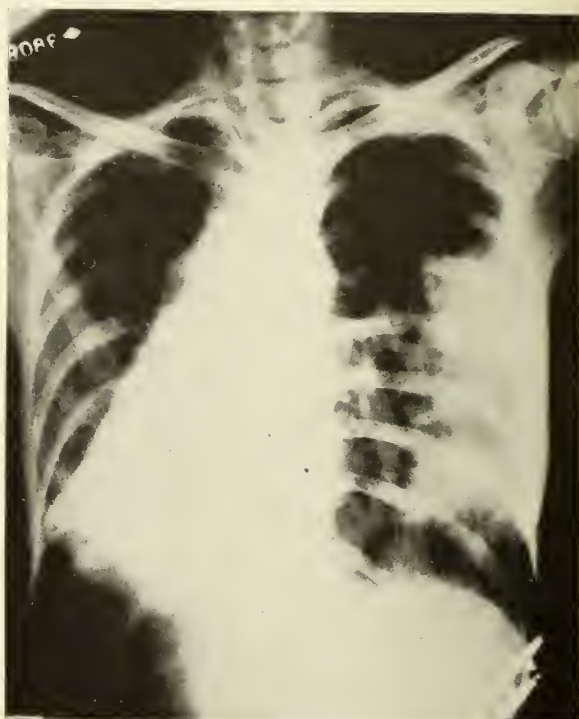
Roentgenogram taken on June 12, 1927, after collapse was much improved but bronchopneumonia had developed on the opposite side. Note the lack of influence of the pneumonia on the position of the diaphragm on the right and on the position of the heart—a distinguishing evidence between pneumonia and atelectasis.
